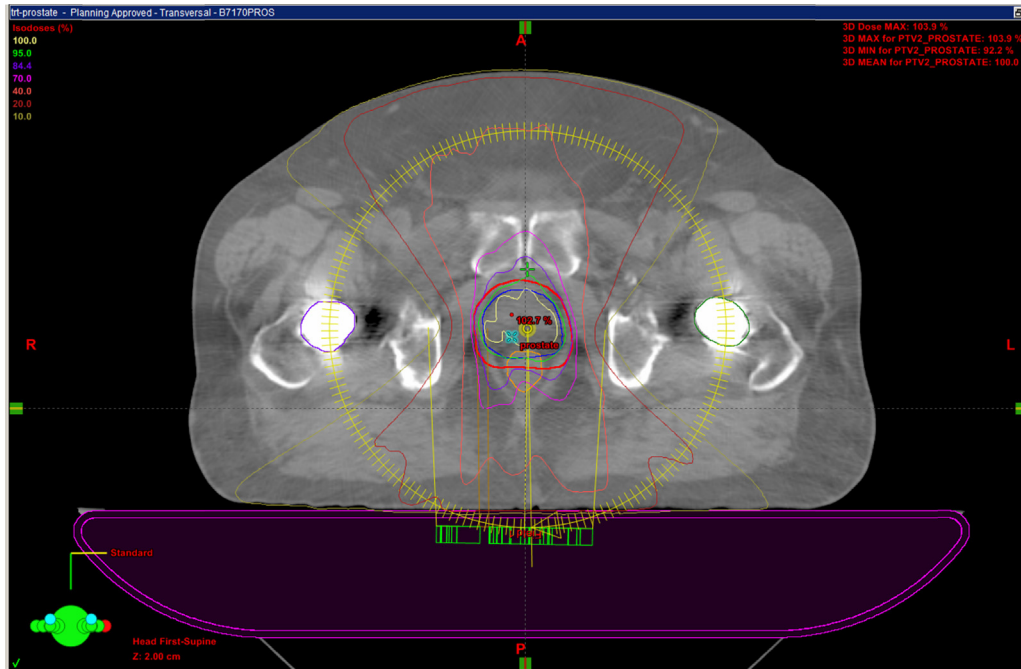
Cross sectional image of CT image on TPS demonstrating the dose distribution of VMAT.
